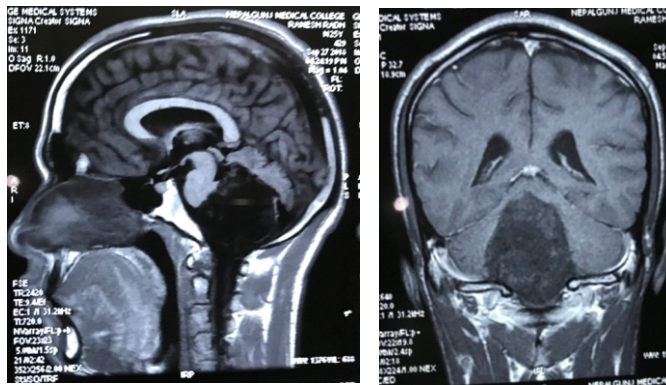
MRI showing lesion in posterior fossa (midline)
